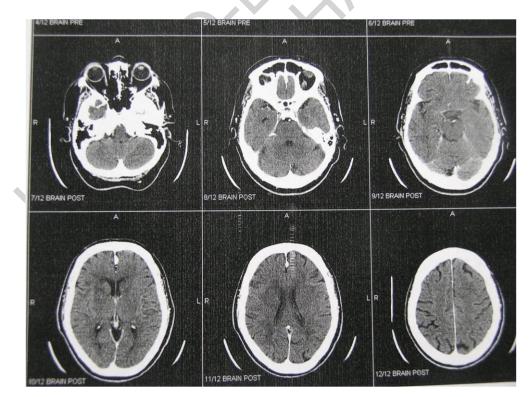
Pre-operative Computed Tomography Angiogram of the brain showing no evidence of an acute infarct
